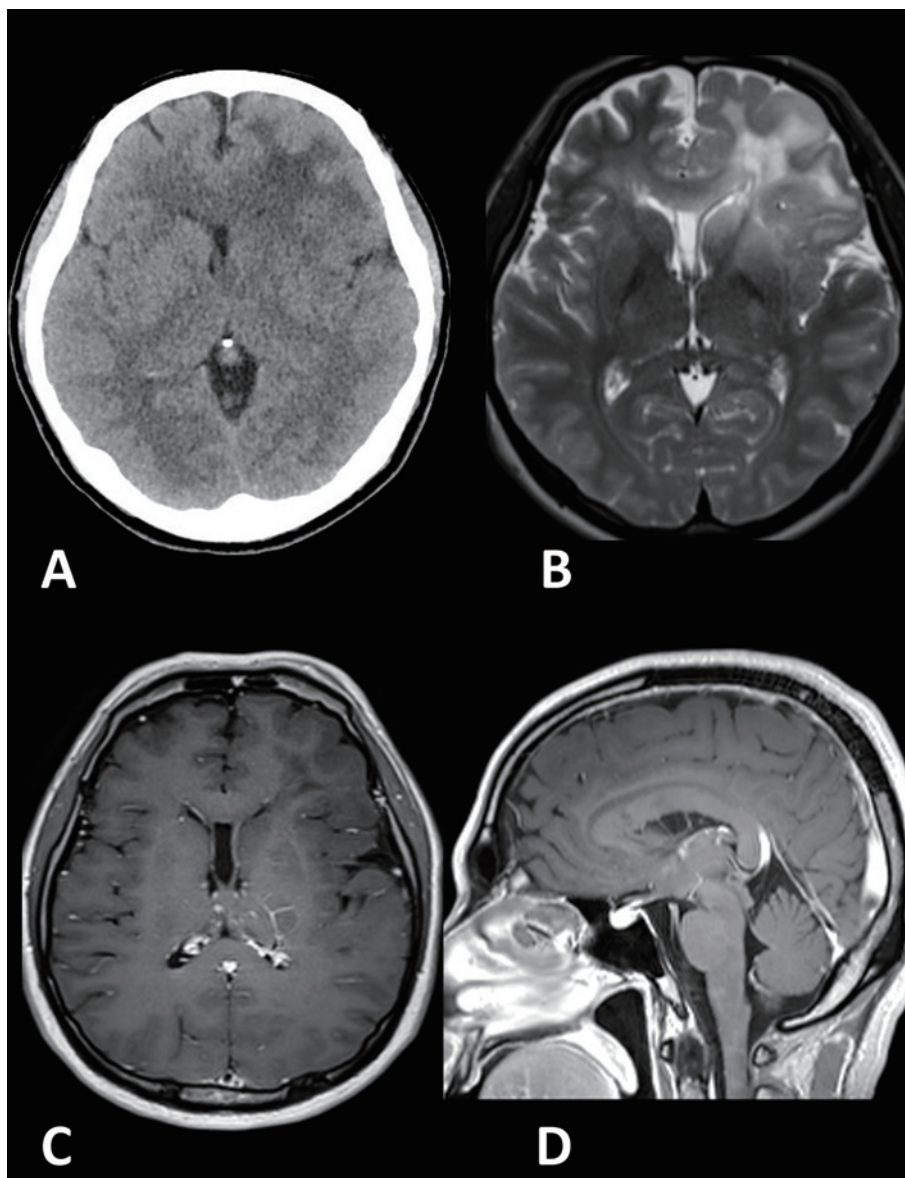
(A) Preoperative brain CT showing the absence of brain shift despite mild brain edema in the left frontal lobe; (B) T2-weighted MR imaging showing that the lesion was located not only in the left frontal lobe but also in the left insular cortex; (C, D) Preoperative Gd-enhanced T1-weighted MR imaging showing the absence of parenchymal and meningeal enhancement. C, axial image; D, sagittal image.
